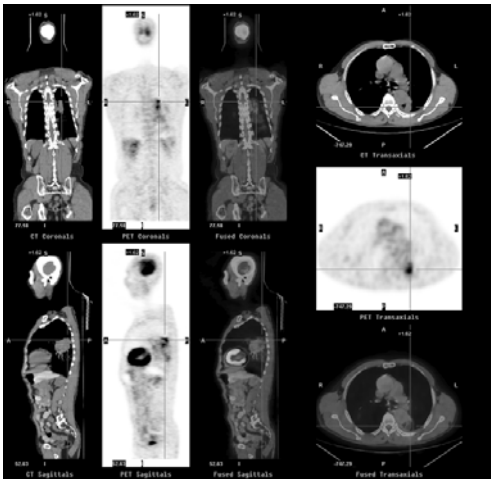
The  $^{18}F$ -FDG-PET/CT images of an adenocarcinoma.
